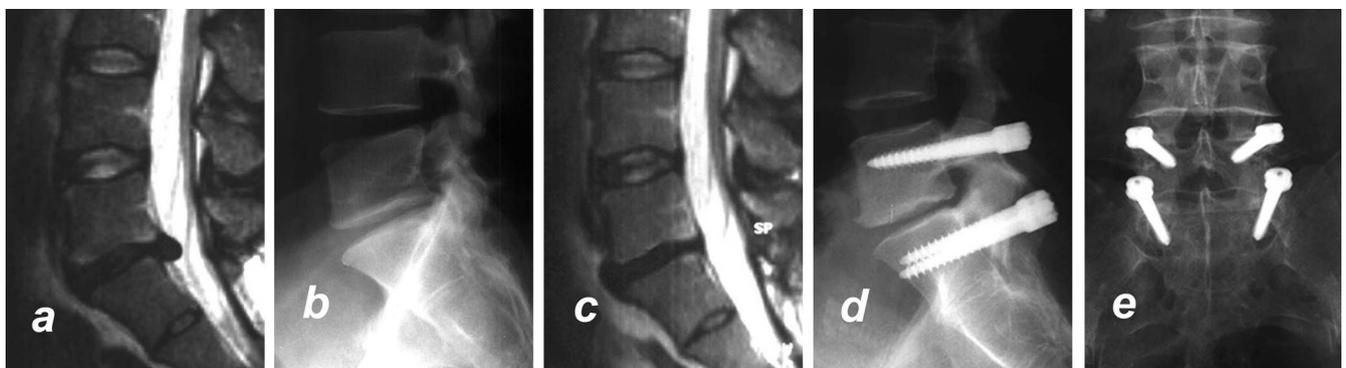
a-e, MRI and radiograph of a 36-year-old female with primary nucleus pulposus prolapse L5/S1, initial osteochondrosis and sensorimotor radicular syndrome preoperative (a, b). Twenty-five months after nucleotomy and DYNESYS stabilization (c-e), no further progression is seen.
